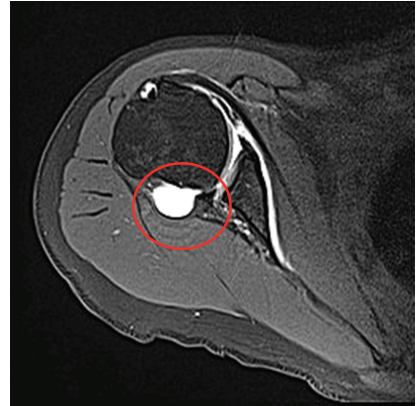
MRI 造影显示后下关节囊隐窝的松弛扩大(红圈所示)。这是无创伤性肩后方不稳的常见特征
